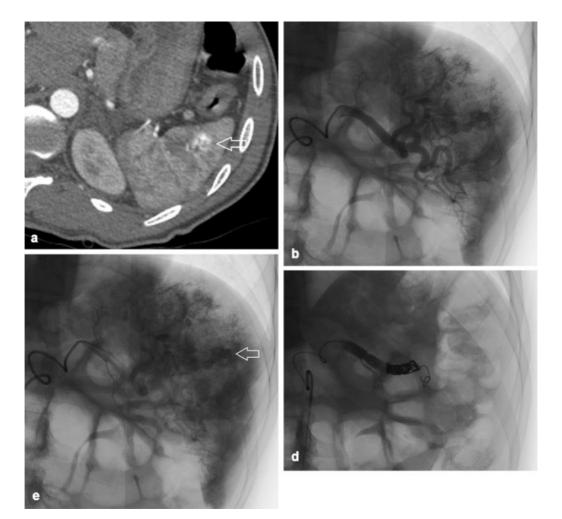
A 24-year-old individual involved in pedestrian–automobile collision. (a) Axial CT showing an arterial blush in the lateral spleen (*arrow*) adjacent to multiple vessels suggestive of a pseudoaneurysm. (b) Splenic angiography showing extravascular contrast at multiple sites. (c) Delayed imaging on angiography shows contrast pooling (*arrow* on one such collection), representative of multifocal pseudoaneurysms. (d) Angiography posttreatment. Given the multifocal findings, it was determined to embolize the spleen proximally using multiple coils beyond the dorsal pancreatic artery. Complete vascular occlusion demonstrated.
